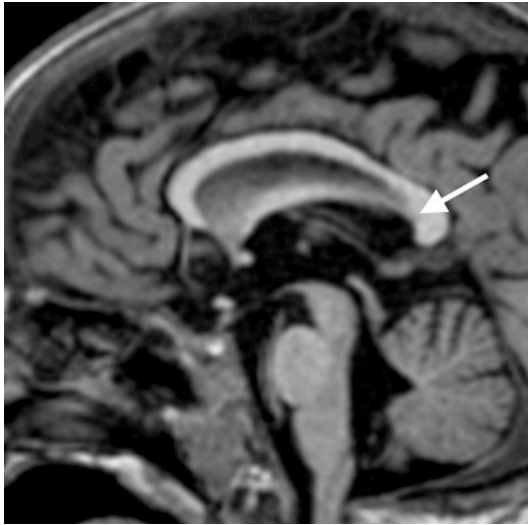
Midline T1 sagittal MRI scan demonstrates a long and thin splenium (arrow) in a 9-month-old boy with tuberous sclerosis. Note also that the whole corpus callosum, including the splenium is thin
